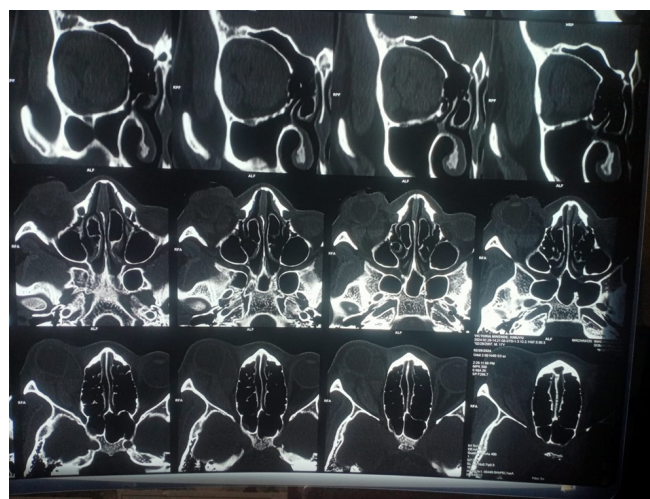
No fractures on the bone window of her CT scan. (© Dr. Lydia Muoki)
